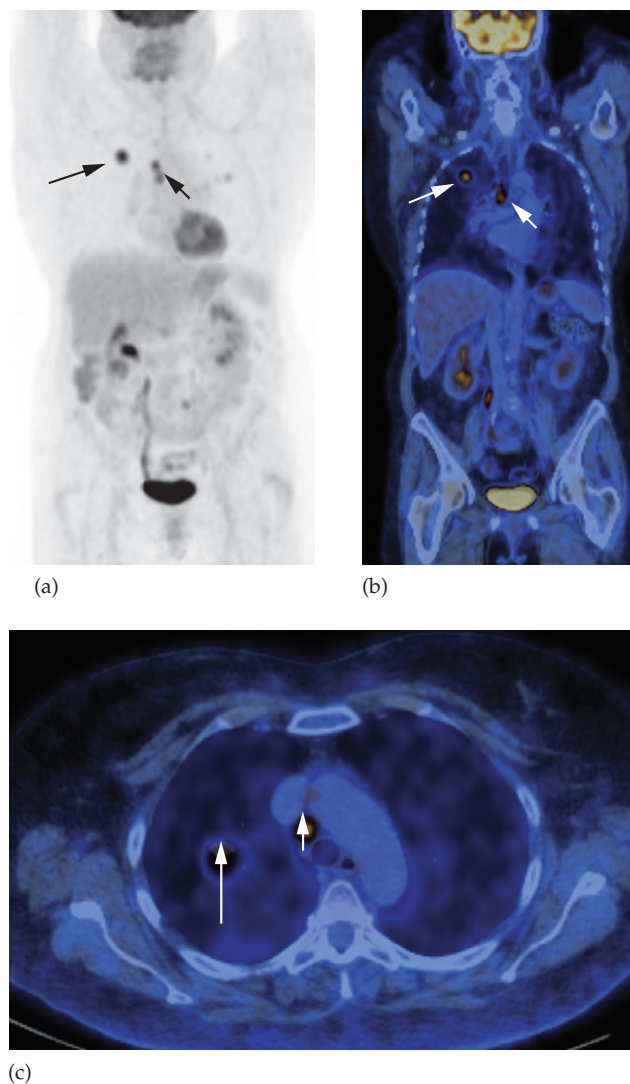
FDG-PET scan of the chest and abdomen showing a focus of high activity in a lung cancer (large arrow) and mediastinal lymph node metastasis (small arrow). (a) Maximum intensity projection (MIP). (b) Coronal fused PET/CT. (c) Axial fused PET/CT. No other abnormality is seen on any of the images. High activity in the myocardium, kidneys and bladder is normal.
